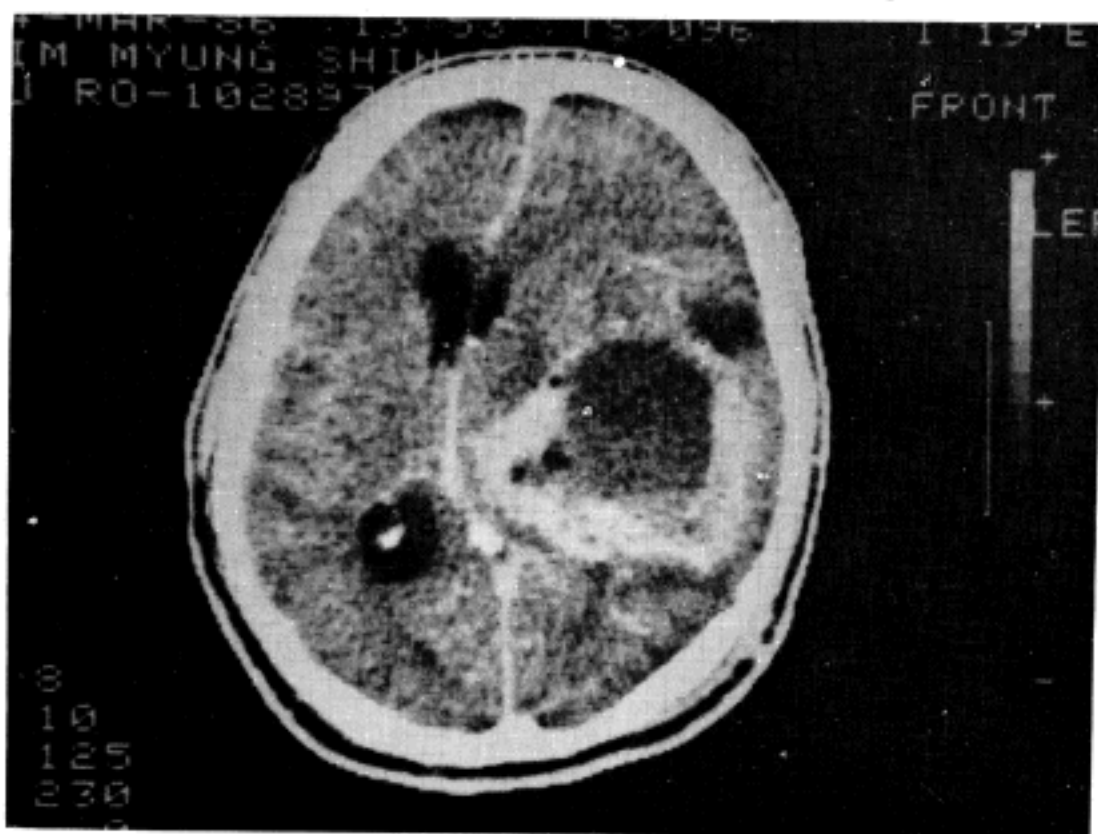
Computed tomography of case 4. Note central low density with highly enhanced irregular margin and perifocal edema in left temporo-parietal area.
